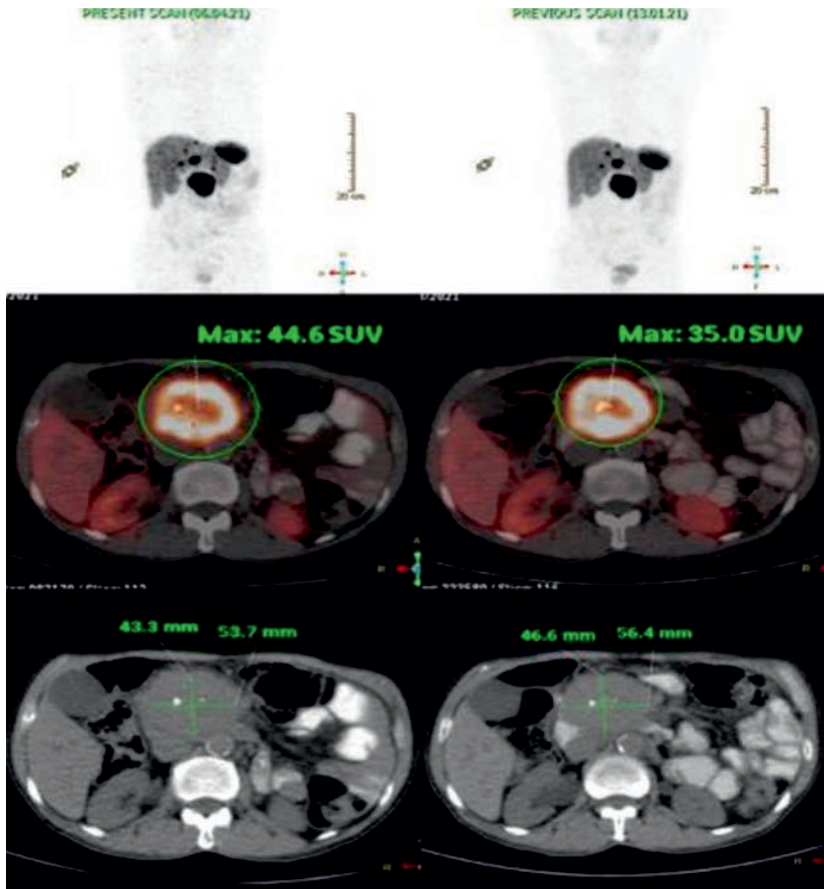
A 48-year-old male with known case of pancreatic head with liver metastases, received 2 cycles of ^{177}Lu -DOTATATE PRRT, ^{68}Ga -DOTATATE PET/CT before and after 2 cycles of therapy shows reduction in SSTR expression, increase in necrosis with stable size.
